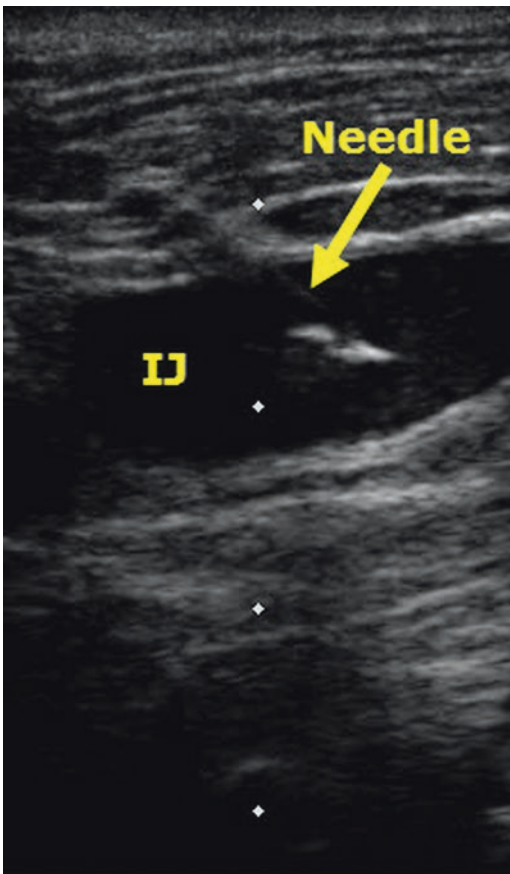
Technique for internal jugular vein access: the needle is visualized with the ultrasound while being advanced. This longitudinal ultrasound view demonstrates the tip of the needle in the lumen of the internal jugular vein. IJ internal jugular vein
